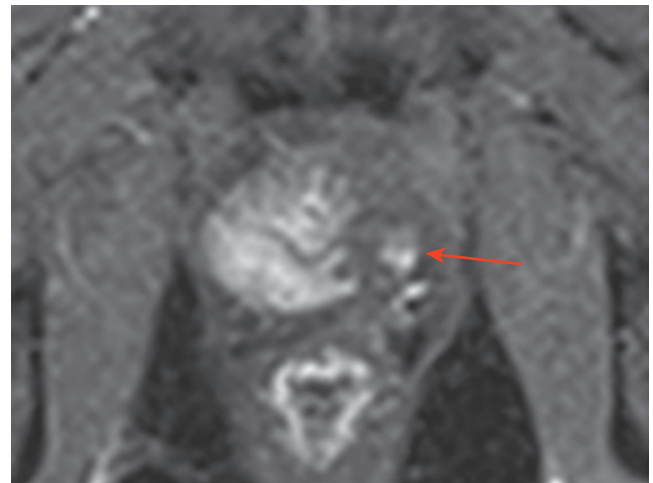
A 12-month scan from another man who underwent focal high-intensity focused ultrasound (HIFU) and was found to have a suspicious area of recurrence (arrow). This was confirmed on targeted biopsies as Gleason 3+4 2 mm. He chose re-treatment with HIFU in a focal manner.
